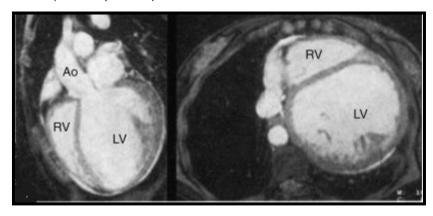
Cardiac Magnetic resonance imaging of dilated cardiomyopathy, Hare JM: Etiologic basis of congestive heart failure.
